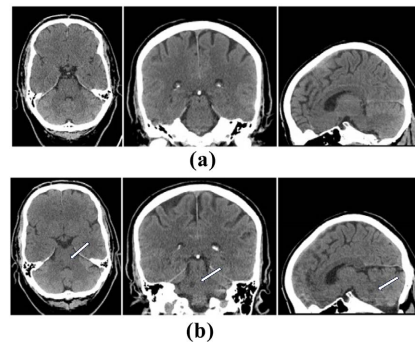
Axial, coronal and sagittal images of a plain CT scan of the pons showing (a) no lesion on admission and (b) a posterolateral hypodense lesion (Arrows) indicating an acute ischemic infarct 3 days later.
